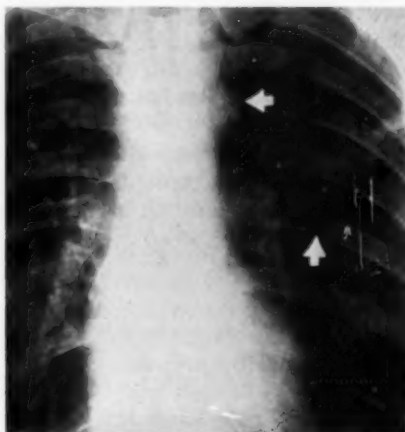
Chest roentgenogram. Note the rib notching (lower arrow) and the prominence along the superior mediastinum on the left (upper arrow).
